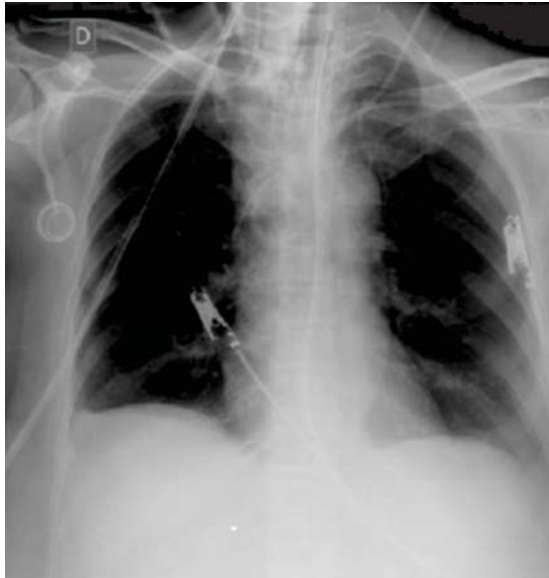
Recent chest radiograph of control showing absence of pleural effusion, and the implanted port for chemotherapy (at the anterior chest region and below the right clavicle).
